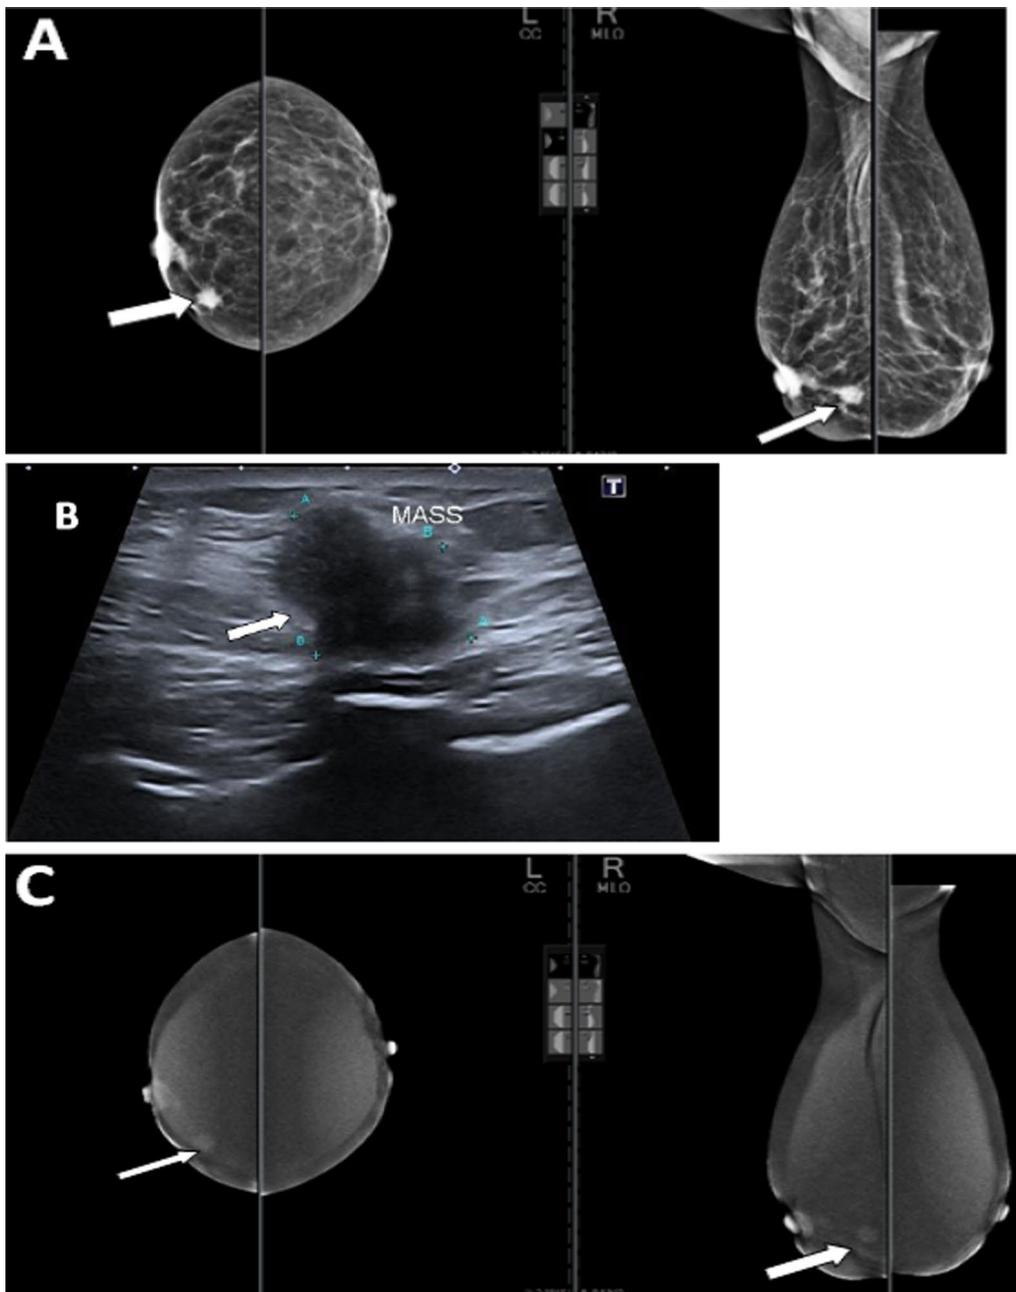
A 64-year-old female patient underwent right CBS for IDC grade II, presenting with right LIQ palpable lump. A Mammography (CC and MLO views) revealed: Breast density ACR 'b'. A hyper-dense lesion in the right LIQ shows irregular borders and multiple speculations showing skin thickening and nipple retraction (white arrow). B Complementary ultrasound revealed: an ill-defined antiparallel hypoechoic mass lesion seen in the LIQ of the right breast. C Contrast-enhanced spectral mammography revealed: enhancing mass in the right lower inner quadrant with evidence of ductal extension (white arrow). Final Diagnosis: Pathology: IDC. Final comment: In this case, both sonomammography and CESM could detect ipsilateral newly developed malignant-looking lesion with CESM also confirmed intra-ductal extension
